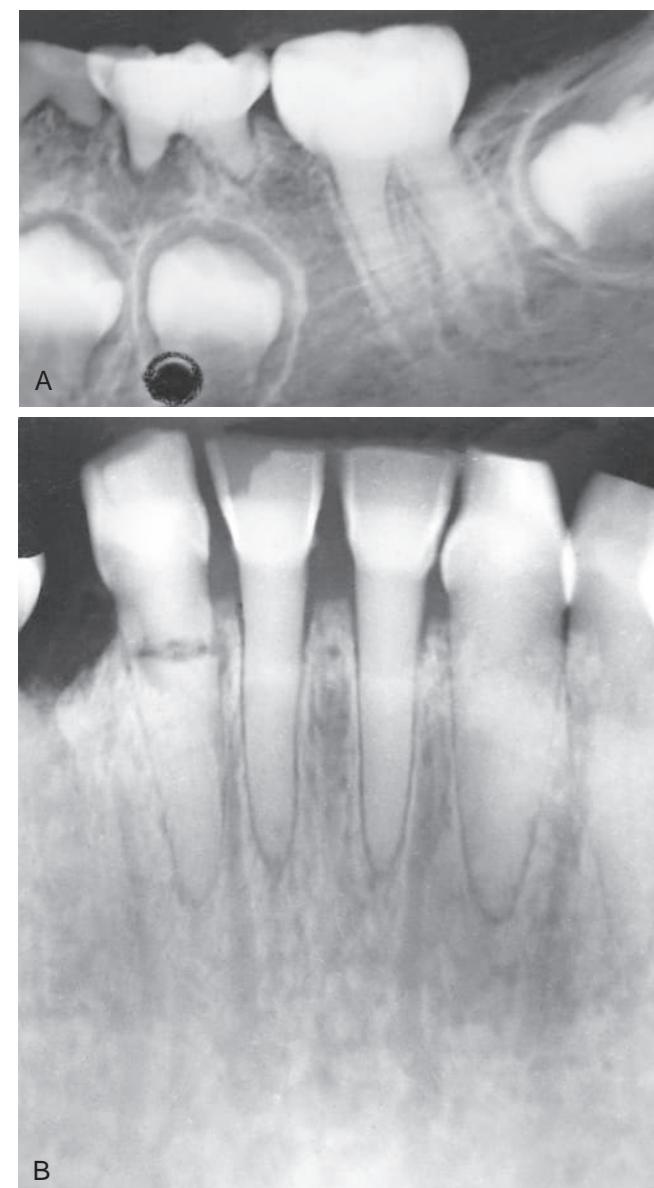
(A) Slender roots with ribbon-like pulp canals and bulbous crowns are characteristic of dentinogenesis imperfecta. The primary molars show periapical rarefaction. (B) Root fractures are common in older patients.
